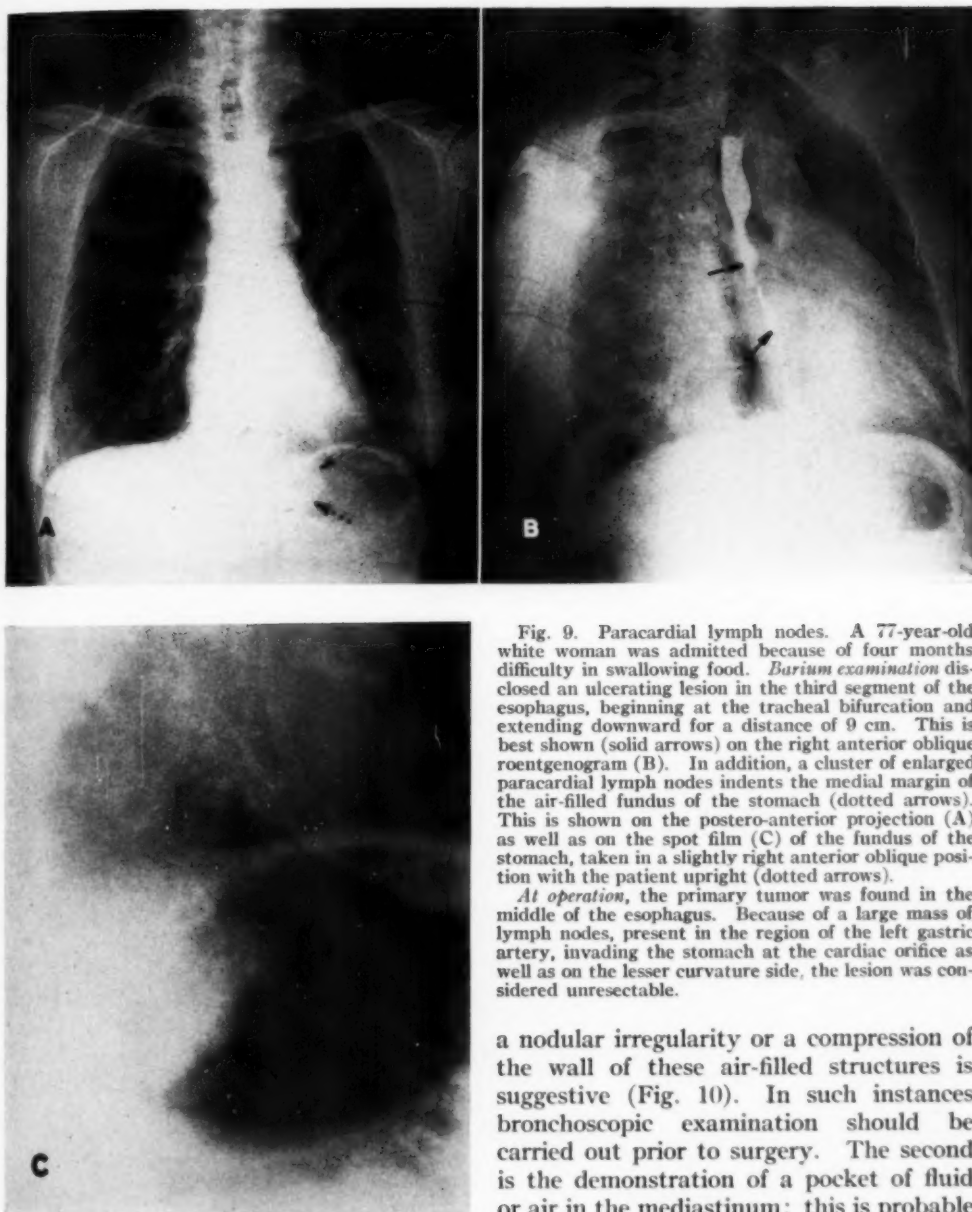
Paracardial lymph nodes. A 77-year-old white woman was admitted because of four months difficulty in swallowing food. *Barium examination* disclosed an ulcerating lesion in the third segment of the esophagus, beginning at the tracheal bifurcation and extending downward for a distance of 9 cm. This is best shown (solid arrows) on the right anterior oblique roentgenogram (B). In addition, a cluster of enlarged paracardial lymph nodes indents the medial margin of the air-filled fundus of the stomach (dotted arrows). This is shown on the postero-anterior projection (A) as well as on the spot film (C) of the fundus of the stomach, taken in a slightly right anterior oblique position with the patient upright (dotted arrows).
